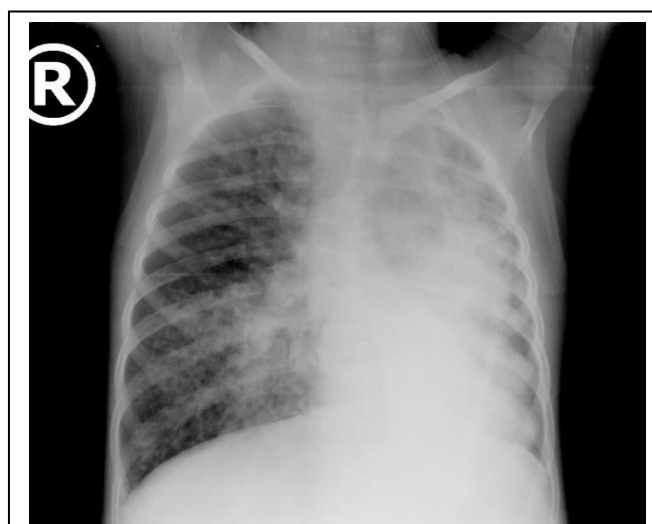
Third X-ray of the lung (age 8 years and 6 months) - The left lung field is almost homogeneously overshadowed. The right lung field has significantly increased transparency, right lung herniation in the left.
